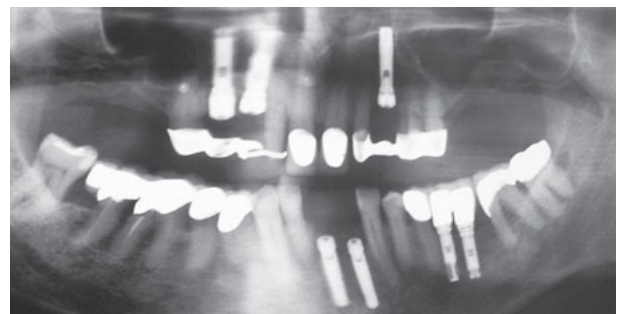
Follow-up panoramic radiograph.
